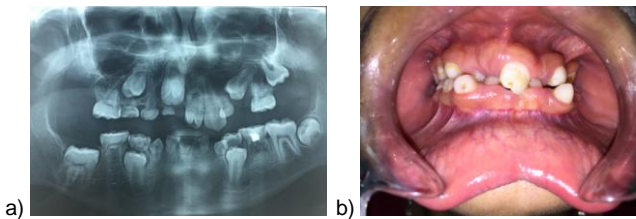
a) Panoramic X-ray showing dental crowding; b) Gum hypertrophy
